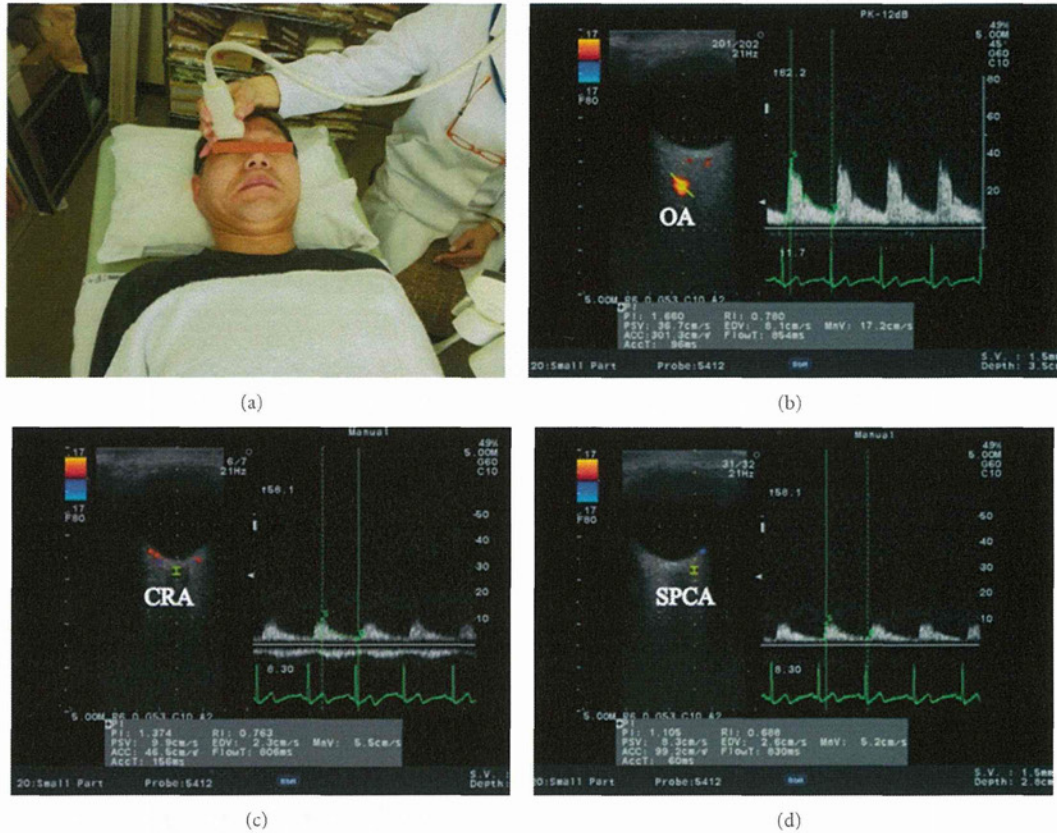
(a) Ultrasound measurement of retrobulbar arteries. 13 MHz linear transducer is attached on the eyelid. Horizontal scans by CDI through the ocular globe showing the (b) ophthalmic artery (OA), (c) central retinal artery (CRA), and (d) temporal short posterior ciliary artery (SPCA). Left: image of the vessel and the position of the artery tracking. Right: Doppler flow and flow velocity (b, c, and d).
